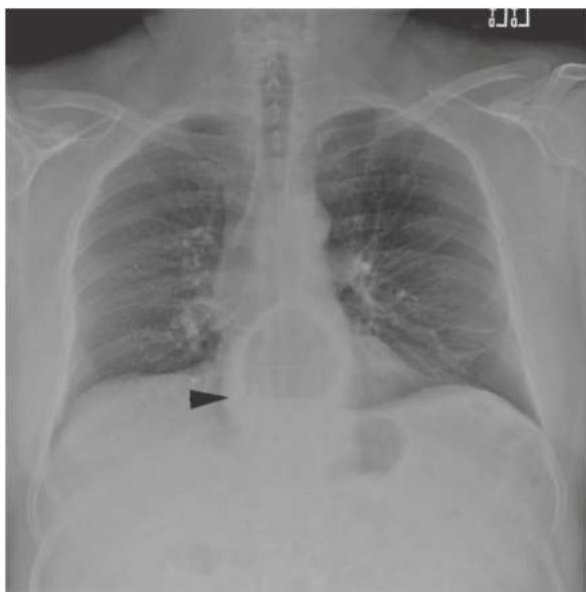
• Chest x-ray demonstrates an air fluid level (arrowhead) consistent with a type III hiatal hernia.
